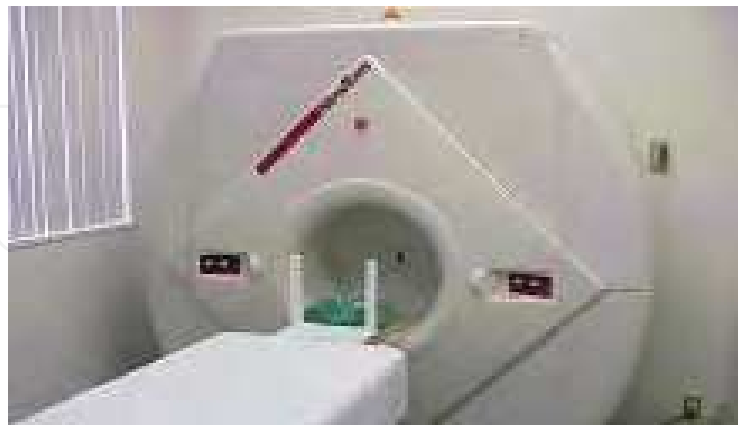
Cone-beam computerized tomography (CBCT) device (NewTom)
